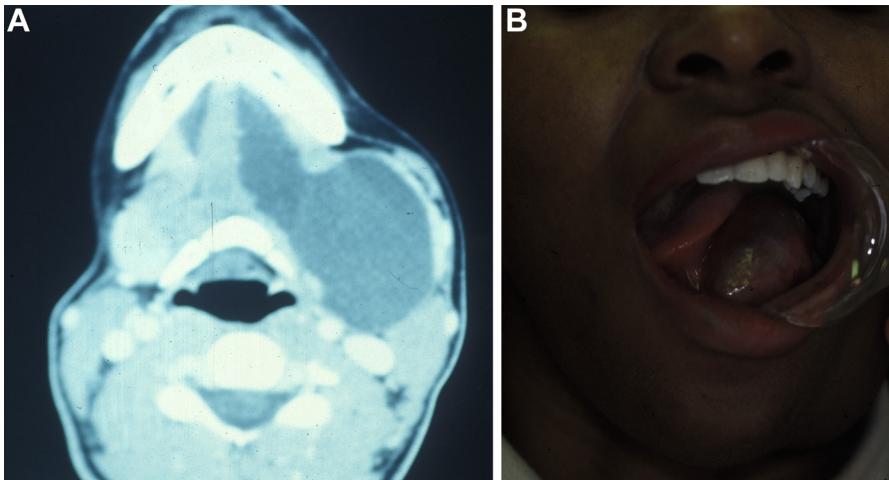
(A) Computed tomography scan of left-sided plunging ranula. (B) Clinical view of large left ranula. Plunging neck mass can be seen in left submandibular triangle.
